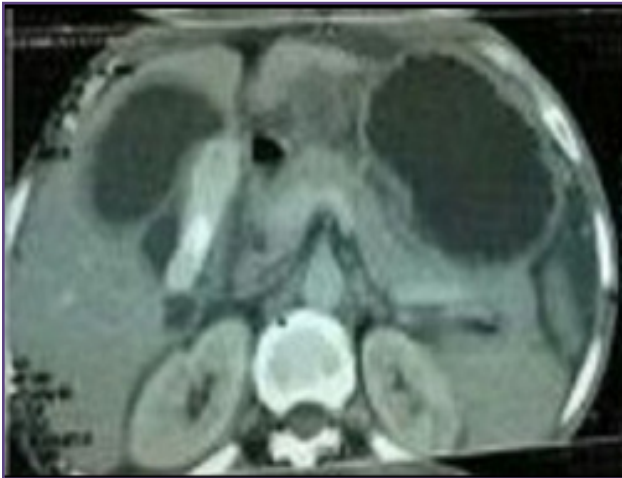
CT abdomen showing distended sludge filled gall bladder with a calculus of 3.5cm diameter.
